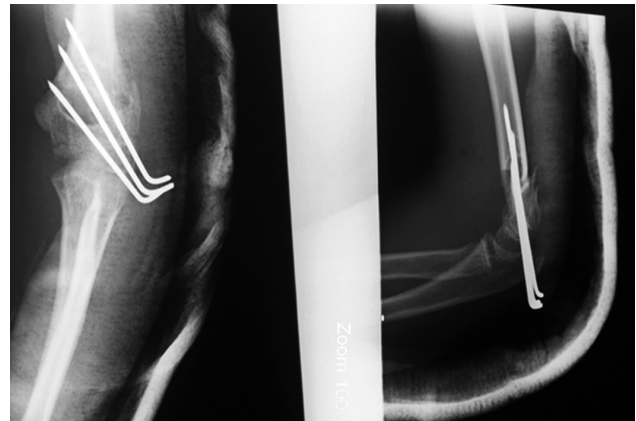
Post-operative X-rays of elbow-AP and lateral views after pinning in displaced humerus fracture in children
